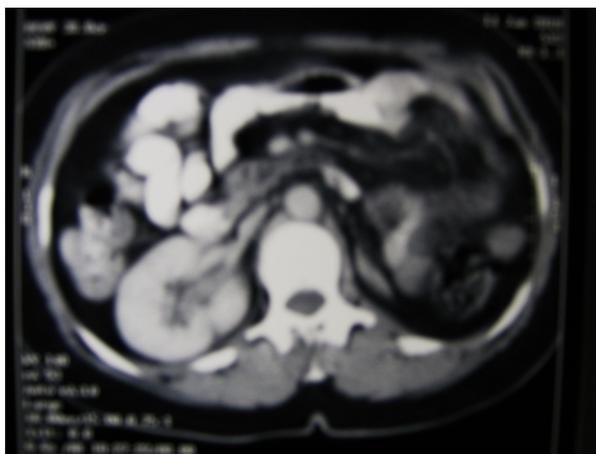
Abdominopelvic CT; absence of left kidney.
